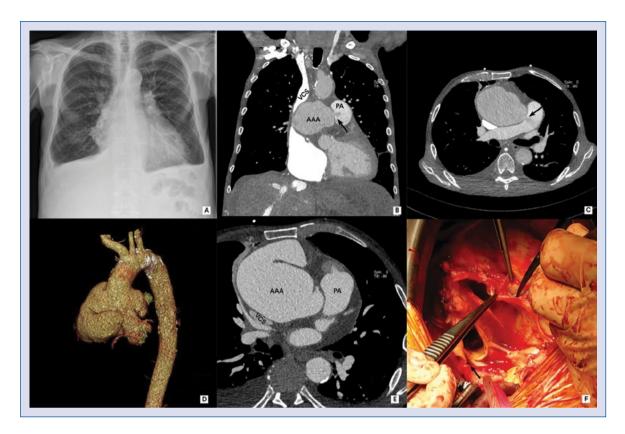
A. Chest X-ray showed widening of the middle mediastinum and double pleural effusion; B–E. Computed tomography angiography revealed an aneurysm with limited dissection, compression of the superior vena cava and communication between the aortic aneurysm and main pulmonary artery (aortopulmonary fistula — arrows); F. Intraoperative view of the aortopulmonary fistula (arrow) and chronic dissection; AAA — ascending aortic aneurysm; PA — pulmonary artery; VCS — vena cava superior.
